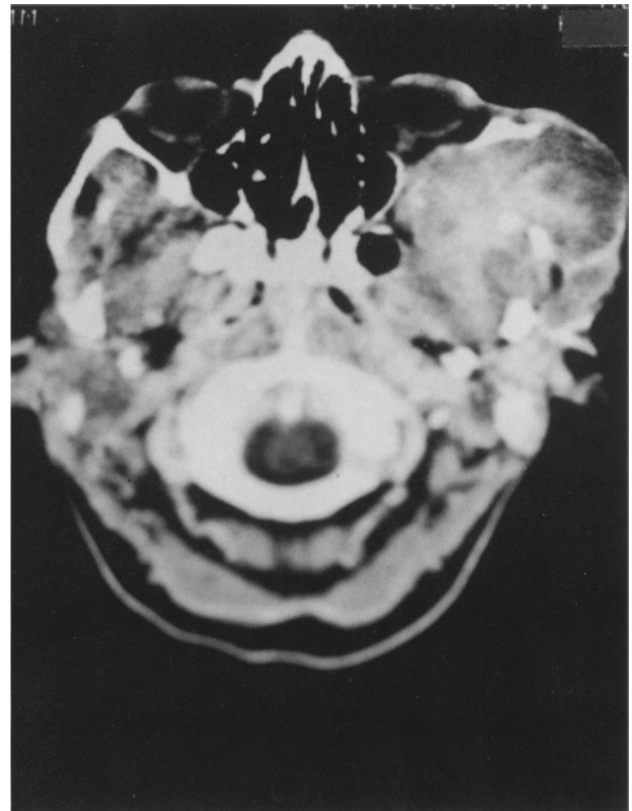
(a) Patient with idiopathic thrombocytopenia. (b) CT scan shows the extent of the tumor. (c) Resection of the tumor with CO<sub>2</sub> laser was successful, with minimal blood loss.
